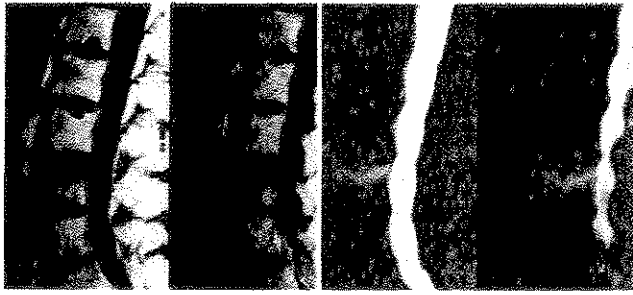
Lumbar spine MRI: *Left*, T_1 -weighted sagittal image. *Right*, T_2 -weighted sagittal image. There is a large area of low (black) signal intensity affecting the bone adjacent to the superior vertebral endplate L4. This area becomes bright (white) with T_2 -weighting. These imaging findings are consistent with bone marrow edema associated with an acute L4 vertebral body fracture.
